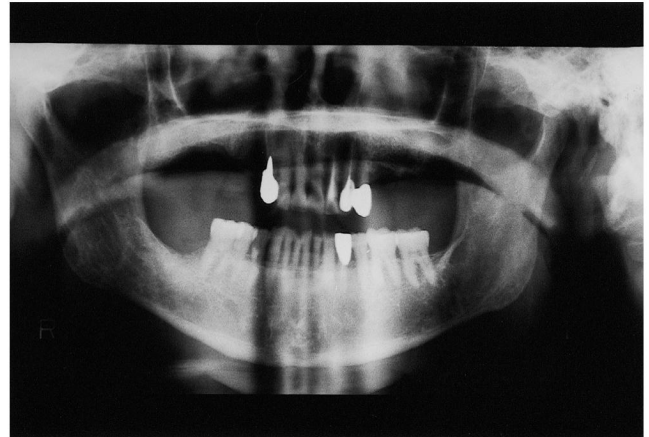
Postoperative Panoramic radiograph. Follow-up radiograph 3 months after surgery showing no evidence of sinus infection.
